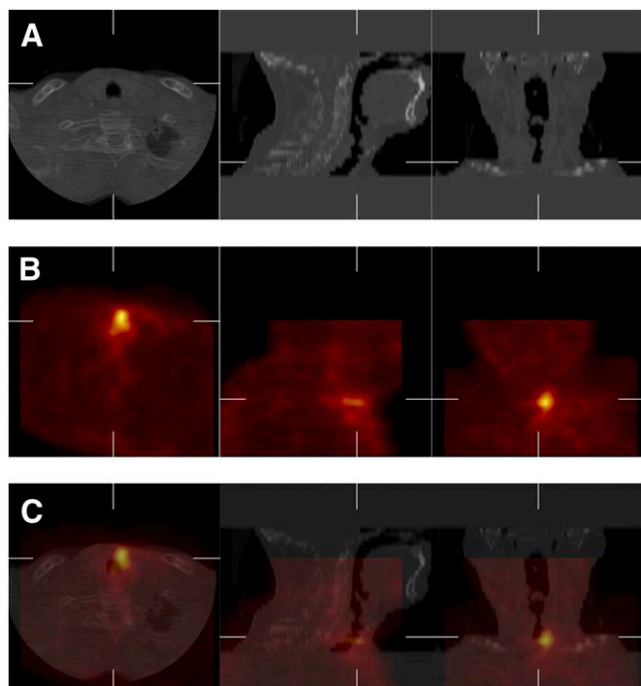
A 62-y-old patient with larynx cancer. (A) Head and neck CT image of patient showing transaxial (left), sagittal (middle), and coronal (right) slices. (B) Head and neck ^{99m}Tc -glucarate SPECT image. (C) SPECT/CT fusion image. CT images show thickening of soft tissues of left side of subglottis with eccentricity and luminal stenosis. Fusion images show intense focal uptake in that region.
